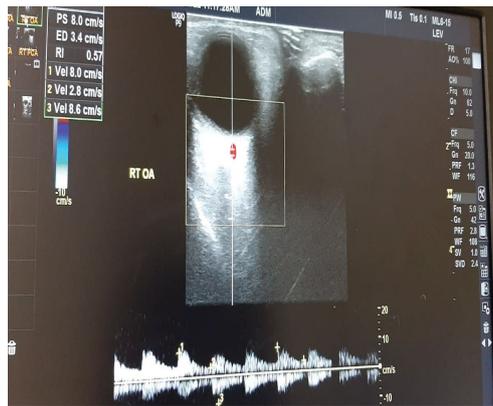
Color Doppler image showing high resistance flow in the ophthalmic artery
